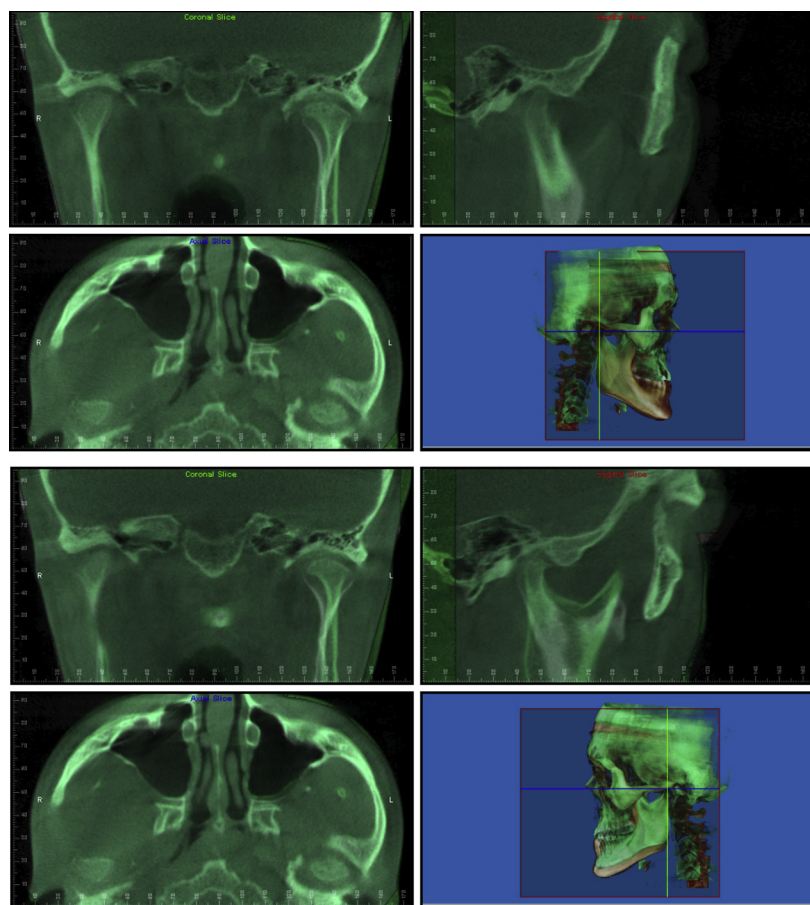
Superimpositions of cone-beam computed tomography images on the cranial base at pretreatment (*white*) and posttreatment (*green*).
